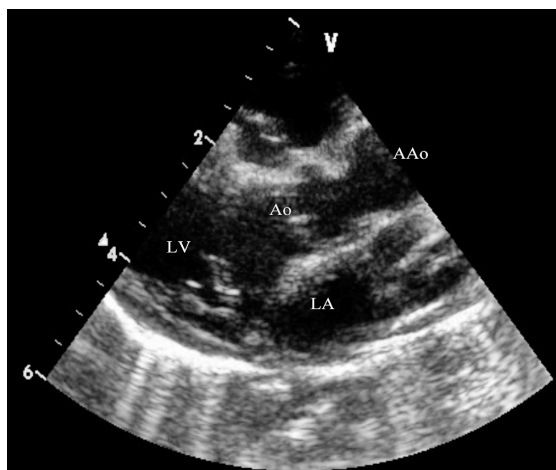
2D echocardiogram (parasternal long-axis view) shows a dilated ascending aorta. The aortic sinus is also prominent. LV: left ventricle; Ao: aortic annulus; AAo: ascending aorta; LA: left atrium
